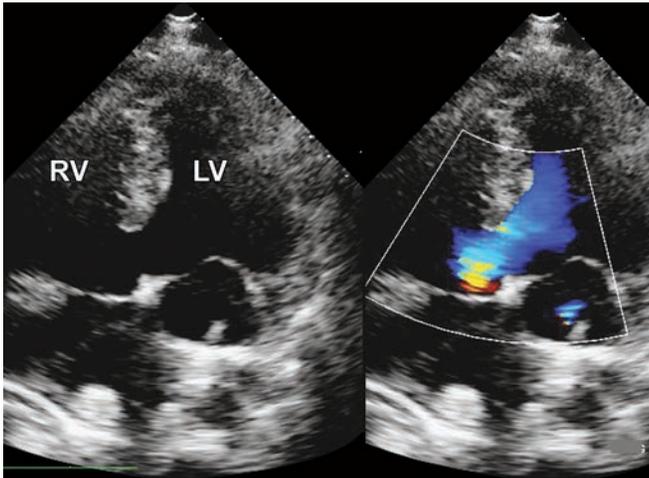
Transthoracic apical 4-chamber view with color Doppler.
